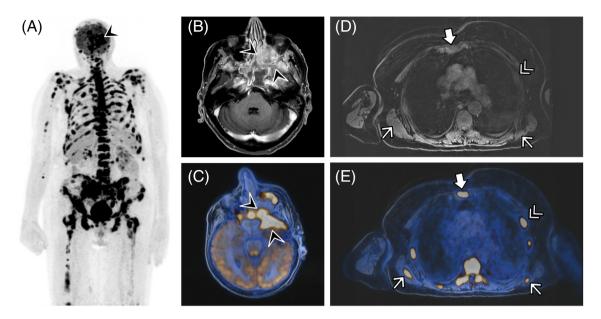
Initial FDG-PET/MRI and synchronous sinonasal/neck MRI staging examination of an 81-year-old female patient with sinonasal undifferentiated carcinoma (SNUC): (A) Whole-body maximum intensity projection of PET shows an intensely FDG-avid sinonasal tumor (black arrow) with FDG-avid soft tissue metastases and disseminated FDG-avid bone metastases. (B) Axial contrast-enhanced, fat-suppressed T1-weighted MR image and (C) FDG-PET/MRI show a large sinonasal tumor expanding into the orbit (black arrow). (D) Whole-body MRI and (E) fused FDG-PET/MRI demonstrate an FDG-avid soft tissue metastasis in bilateral latissimus dorsi muscles (white arrows), a bone metastasis in the sternum (bold white arrow) and bone metastasis in the sixth left rib (white double arrow). Owing to PET findings, the patient then underwent best supportive care. FDG-PET/MRI, 2-[¹⁸F]-fluorodeoxy-D-glucose positron emission tomography/magnetic resonance imaging [Color figure can be viewed at wileyonlinelibrary.com]
